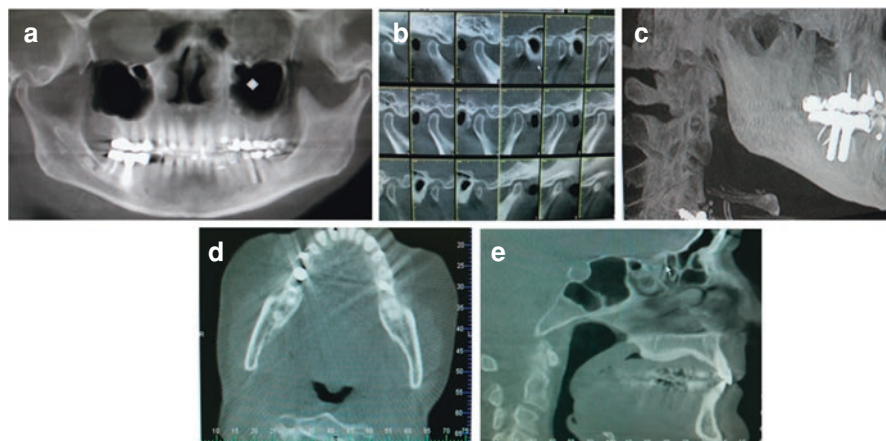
(a) The upper left figure is a panoramic X-ray indicating multiple restorations with slight gonial angle. (b) The upper center figure is tomography indicating the mandibular condyles slightly posteriorized in temporal fossa. (c) The upper right figure is a lateral cephalometric view showing a loss of curvature of the neck. (d) The lower left figure is the cross section of the oropharyngeal airway indicating narrowing. (e) The lower right figure indicates narrowing of the oropharyngeal airway at the soft palate and base of the tongue
